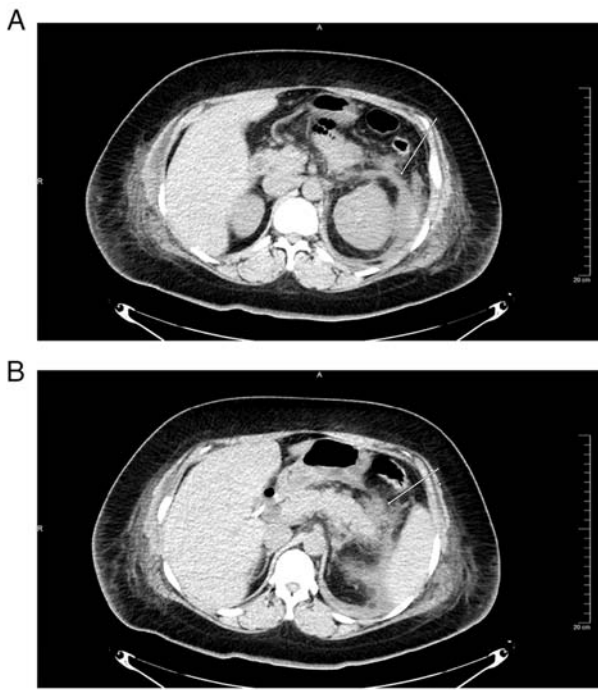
Abdominal computed tomography images demonstrating (A) peripancreatic fat stranding (arrow) and (B) left anterior renal vein thickening (arrow).
